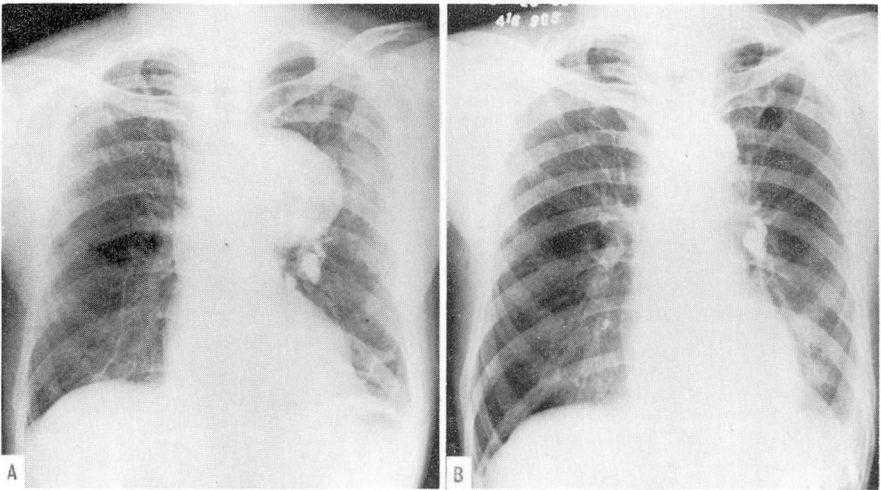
A, Preoperative, and B, postoperative roentgenograms in a 57-year-old professional golfer. The patient's hospitalization was precipitated by severe, progressive, chest pain, and this aneurysm is known from serial roentgenograms to have enlarged rapidly. At operation there were several areas of extreme thinness, and rupture was imminent.
